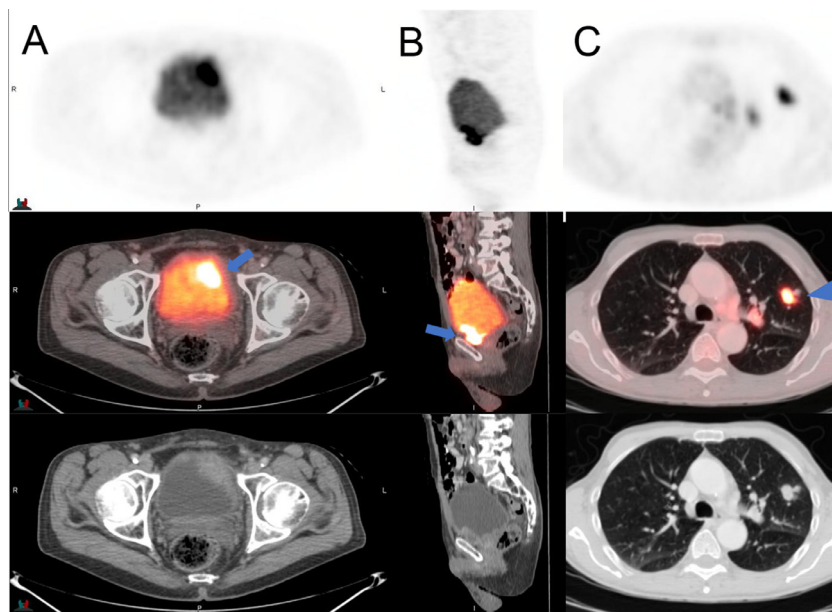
A 68-year-old-man with hematuria was found to have two foci of muscle-invasive urothelial carcinoma with mucinous features, high grade, invading the prostate on transurethral resection. Staging PET/ceCT reidentifies these contrast-enhancing lesions at the bladder neck (A, axial images; arrow) and base (B, sagittal images; arrow) measuring 4.1 × 4.6 cm with intense FDG uptake (max. SUV 9.6; reference liver SUV was 2.6). There are incidental findings of FDG avid left hilar node and left upper lobe pulmonary nodule (C, axial images; arrowhead), 1.2 × 2.3 cm with max. SUV 6.8. It revealed metastatic urothelial carcinoma at subsequent biopsy. The patient was treated with palliative chemotherapy with cisplatin and gemcitabine but died 5 months later.
